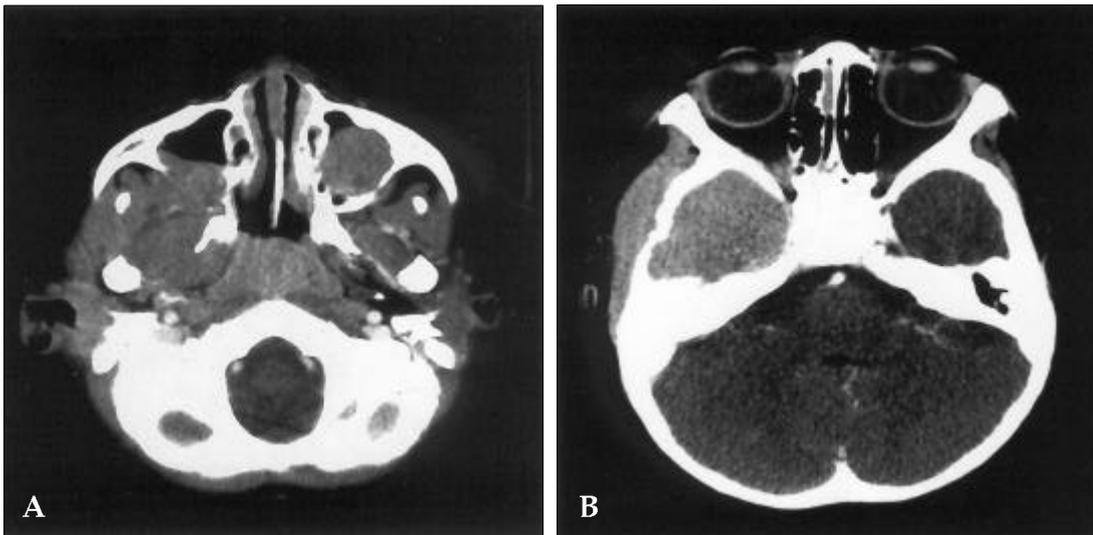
PNS (A) and brain CT (B) show a well marginated homogenous enhancing lesion in the right middle cranial fossa and infratemporal fossa, with mild destruction of the adjacent bony cortex. The lesion elicits no mass effect on the brain parenchyma.
